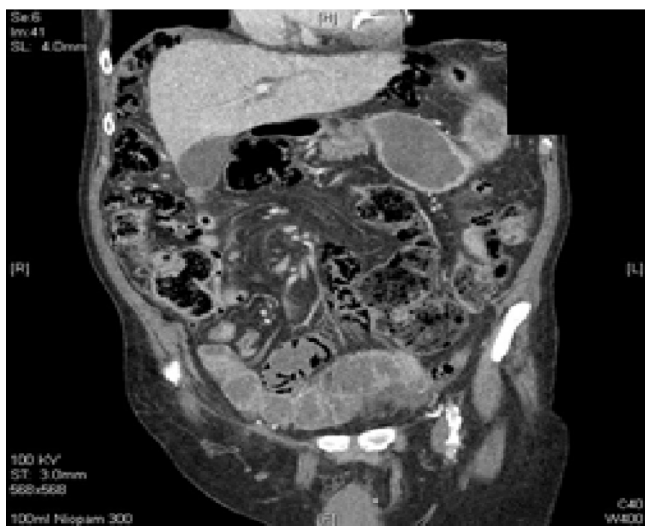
CT imaging reveals gross mesenteric air.
